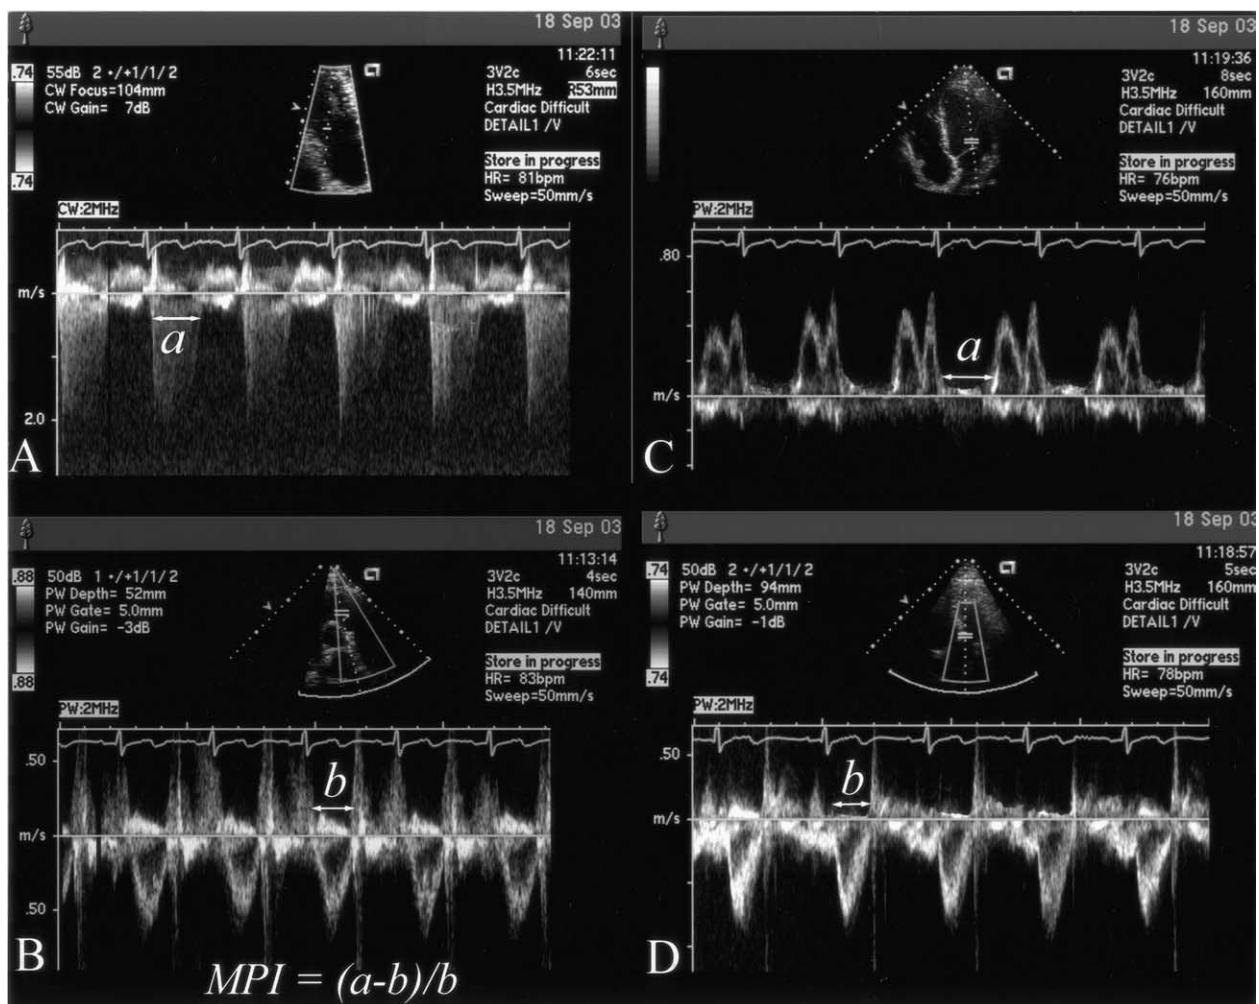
Spectral Doppler recordings of tricuspid regurgitation jet (A), right ventricular outflow (B), mitral inflow (C), and left ventricular outflow (D) in a patient with previous device closure of a secundum atrial septal defect. Intervals *a* and *b* are used to calculate myocardial performance index (MPI) for the right and left ventricle as per the formula: $MPI = (a - b)/b$. bpm = beats/min; CW = continuous-wave Doppler; HR = heart rate; PW = pulsed-wave Doppler.
